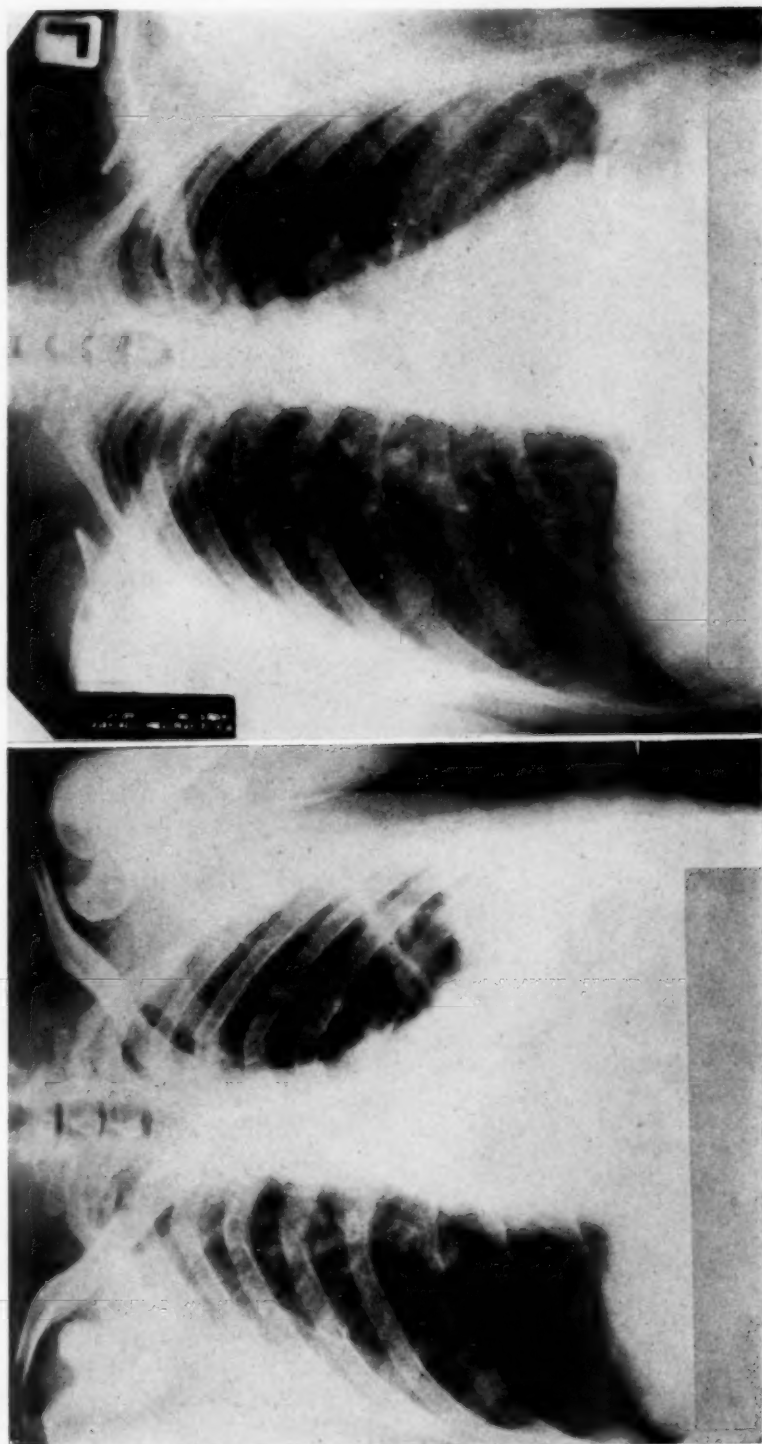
Roentgenograms of case 12 (left, November 13, 1944; right, November 30, 1944). Onset of empyema November 10, 1944. Four thoracenteses were done between November 13 and November 16, 1944. The last roentgenogram showed minimal amount of pleural thickening.
